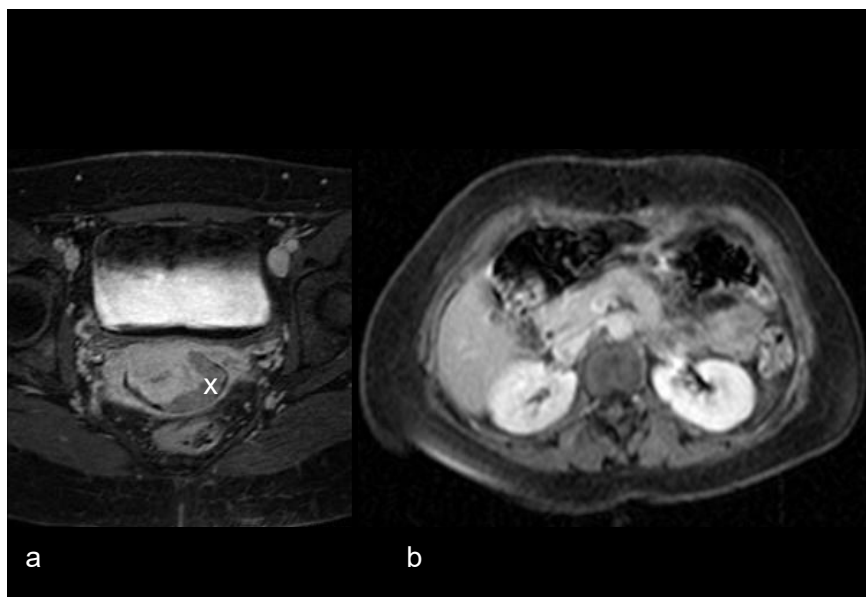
MR protocol C: T1-weighted contrast-enhanced transaxial images of the pelvis (a) and the upper abdomen (b), tumour is indicated with an “x”.
